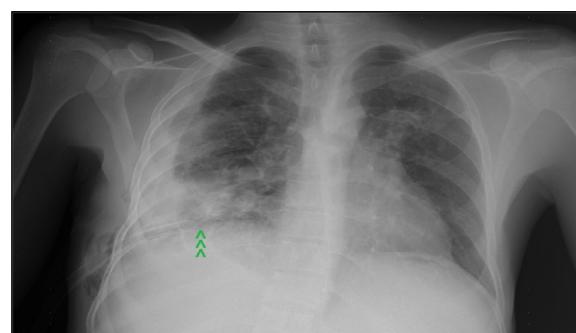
Posteroanterior chest X-ray showing relative expansion of the right lung and chest tube *in situ* (triple arrow heads)
